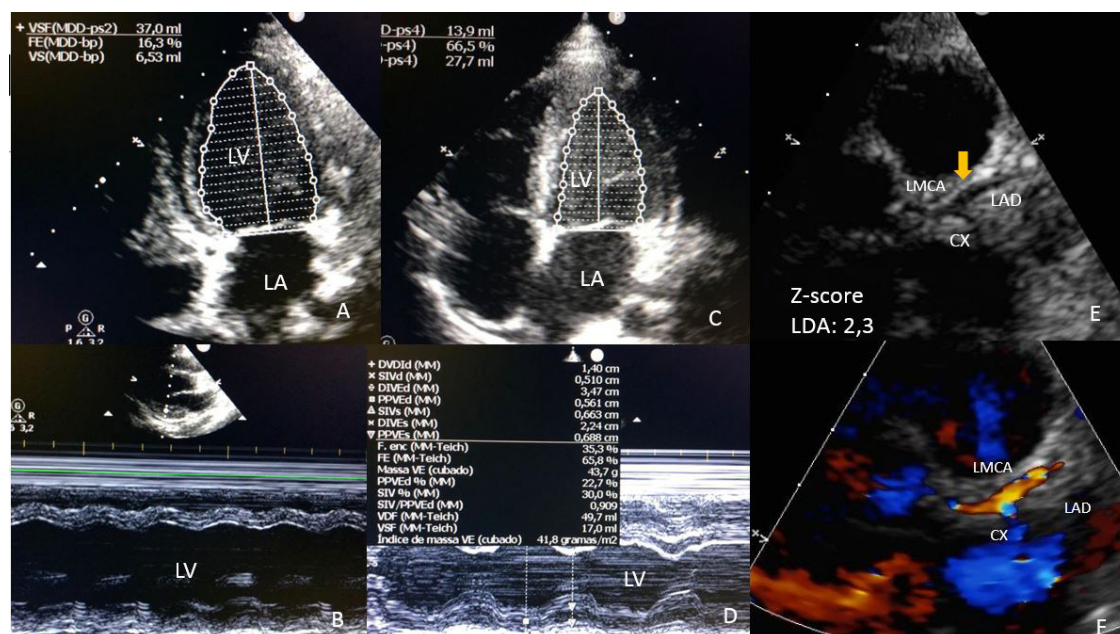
Transthoracic echocardiogram of the boy with Kawasaki-like showing severe left ventricular dysfunction by Simpson (A) and Teichholz (B) and significant improvement after treatment (C,D). LDA dilation (z-score : 2,3) with increased brightness and refringence of the left coronary wall on the two-dimensional (E) and on the color Doppler (F). LV: left ventricle; LA: left atrium; LMCA: left main coronary artery; LAD : left anterior descending coronary artery, CX: circumflex coronary artery.
